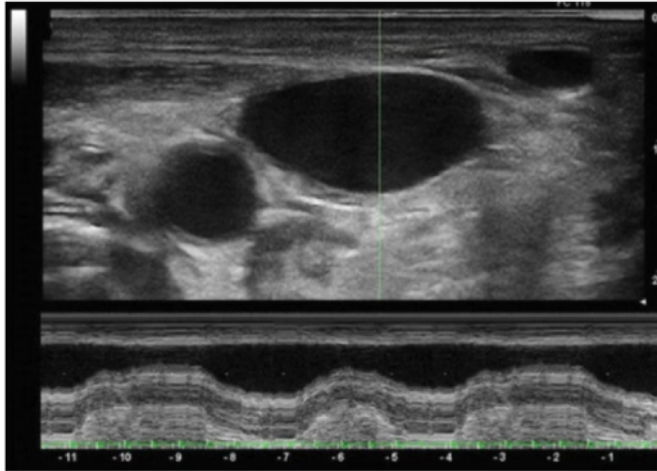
Ultrasound measurement of internal jugular vein variation as an alternative to IVC assessment.
